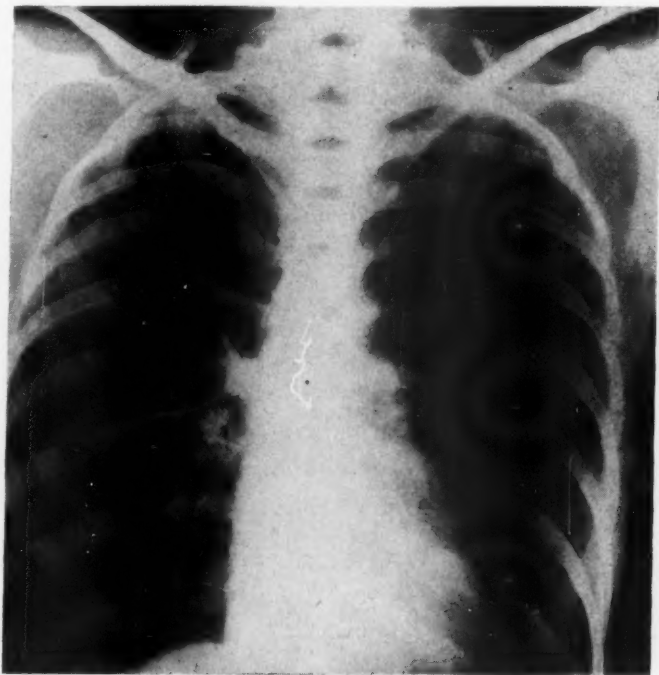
Case 4: Five weeks after admission, the clinical and roentgenologic evidence of infection are gone and a cystic shadow remains.
